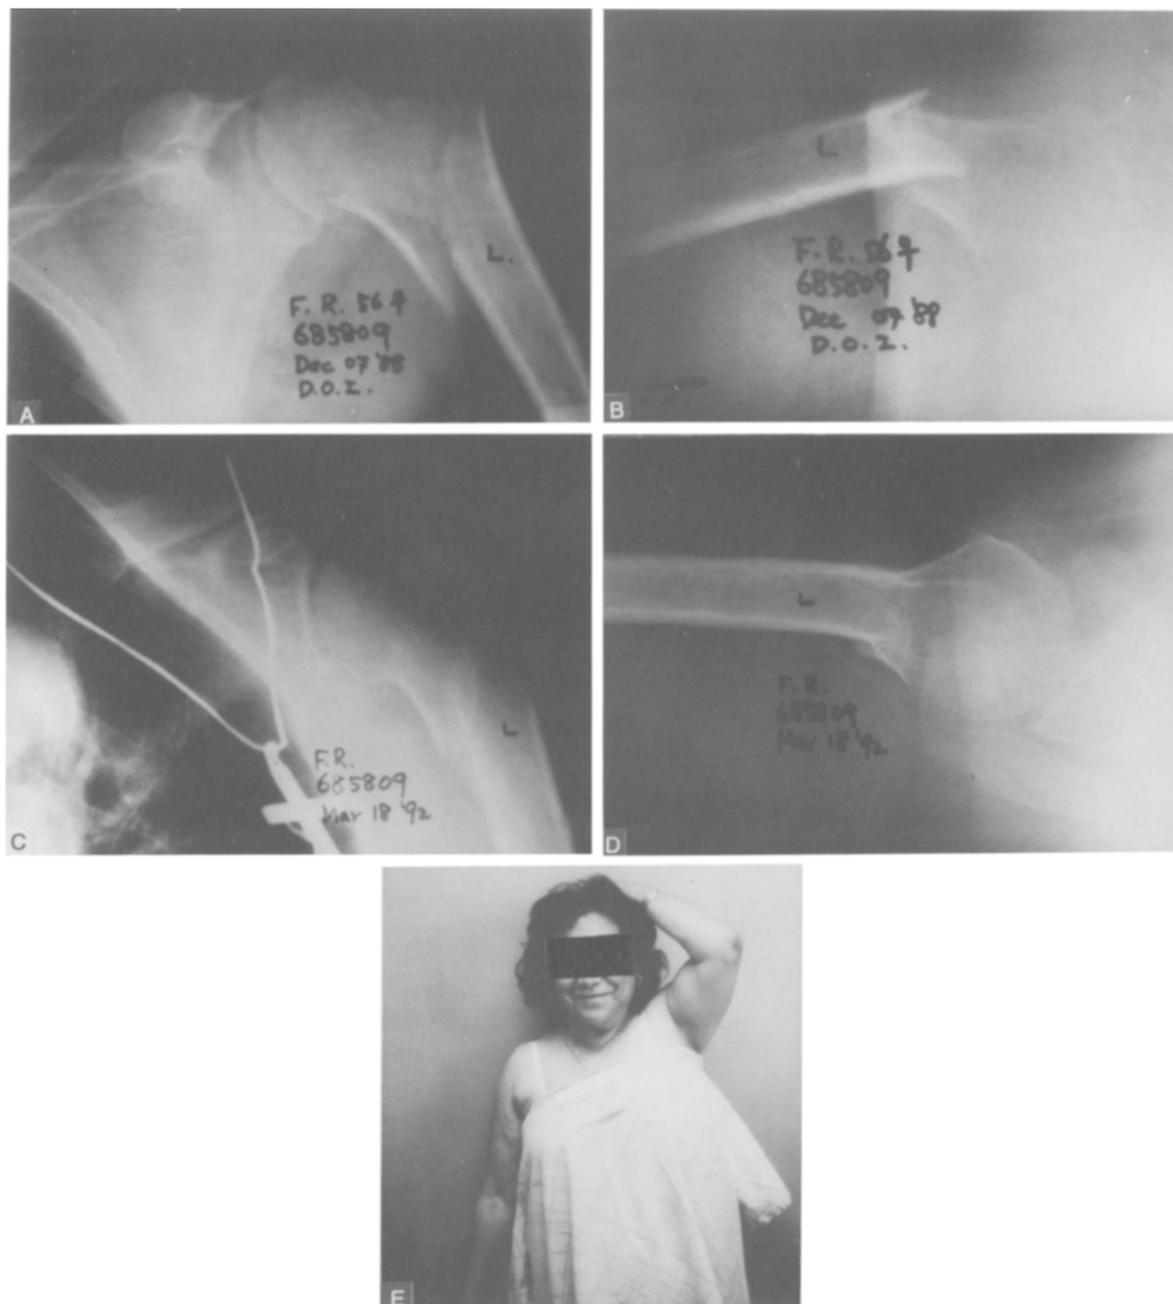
Fifty-six-year-old woman who was injured by motor vehicle accident. Sling was applied, and isometric and pendulum exercises were begun 4 days after injury. A and B, Initial radiographs show comminuted surgical neck fracture with lateral displacement of shaft and anterior angulation. C and D, Anteroposterior and lateral radiographs made 4 years later demonstrate union with good alignment. E, Photograph made 4 years after injury shows useful range of motion, with score of 65 points.
